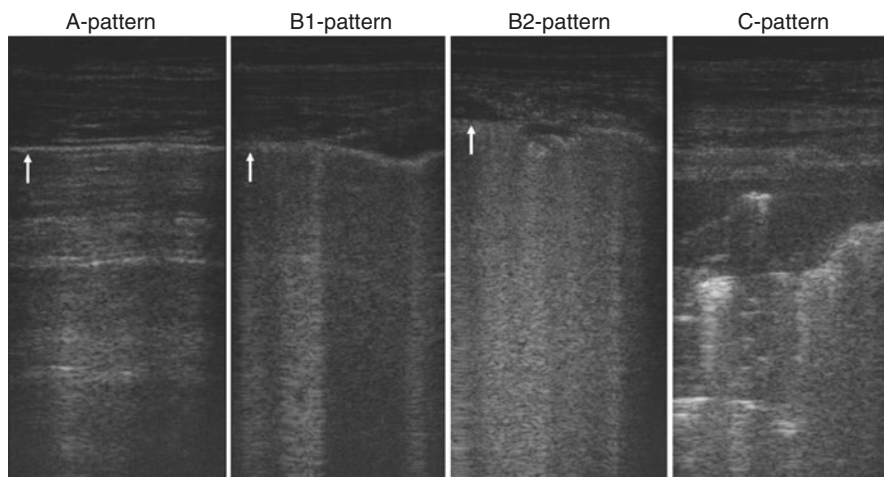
Lung ultrasound score patterns. White arrows indicate the pleura in the ultrasound images
